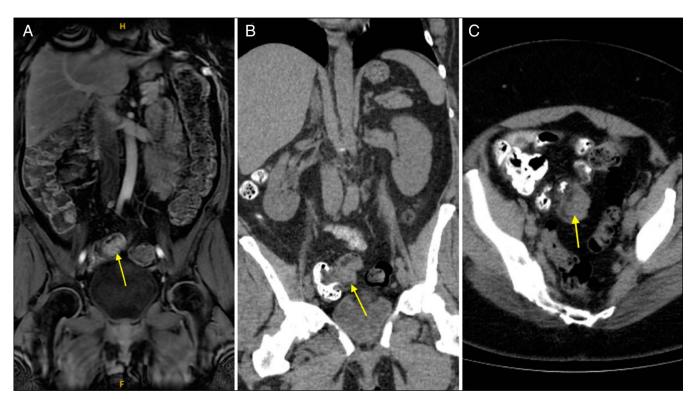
Magnetic resonance enterography (A) and abdominal computed tomography with contrast (B, C) revealing a solid enhancing mass with filling defect at the cecal tip measuring $3.4 \times 2.5 \times 3.4$ cm with proximity to the appendiceal orifice.
